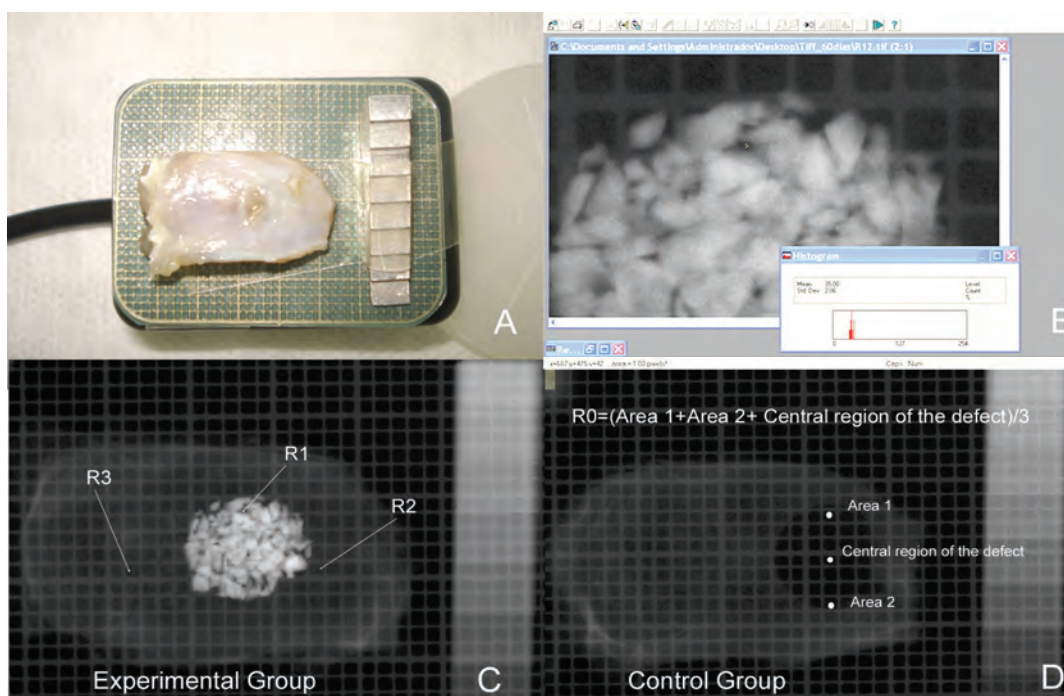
Determination of radiographic density using Image Tool® 3.0. software.
